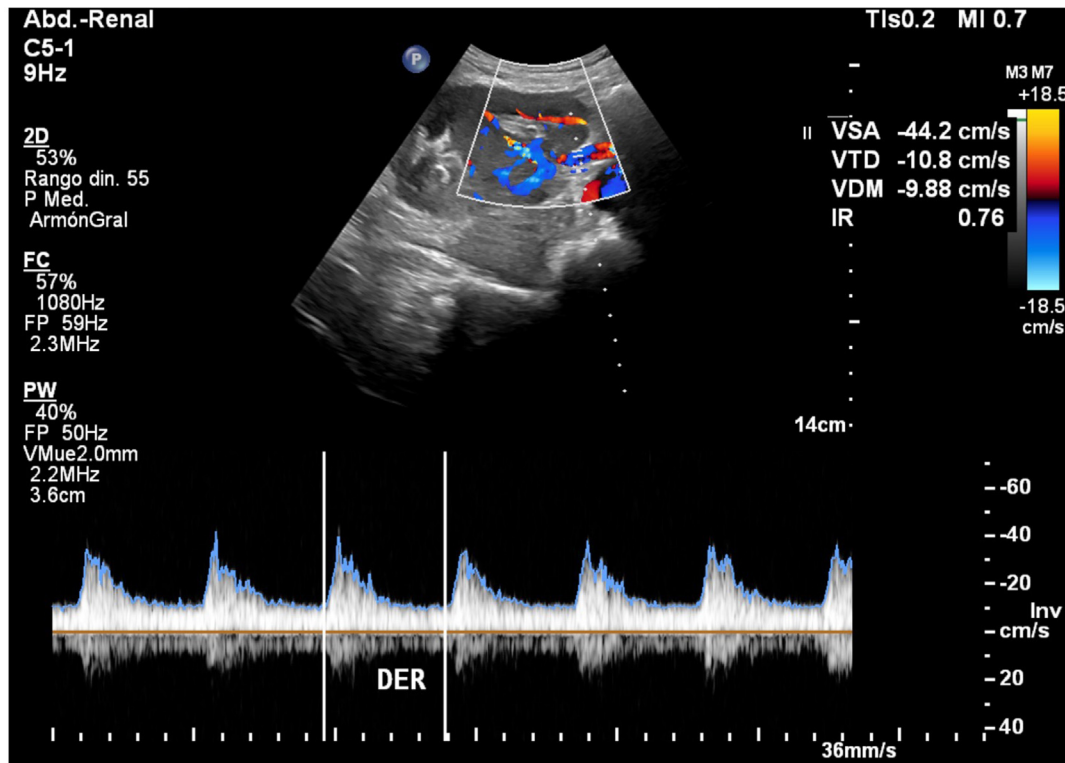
Twenty-four-month follow-up renal duplex ultrasound confirming the adequate patency of the renal artery (RA) with hemodynamic parameters within normal range.
